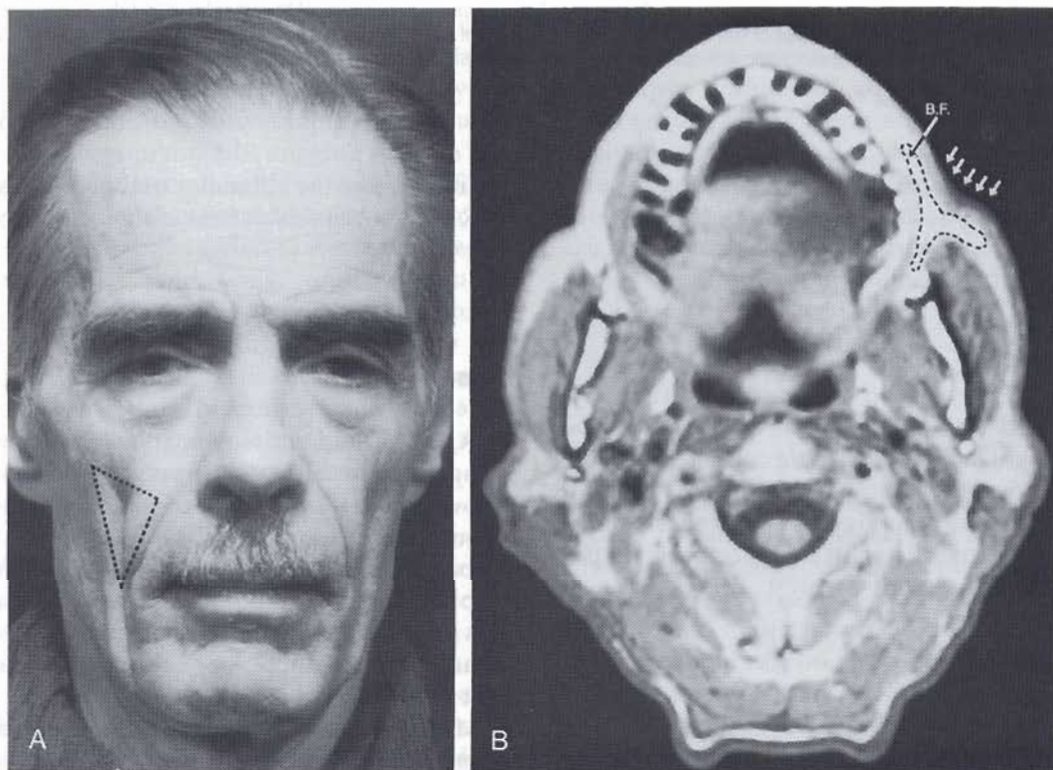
A, Case 4. A 67-year-old man with a midfacial depression localized to the right submalar triangle. B, The MR imaging findings of the midfacial depression seen in the photograph correlate to clinical findings. Arrows indicate area of facial depression.
